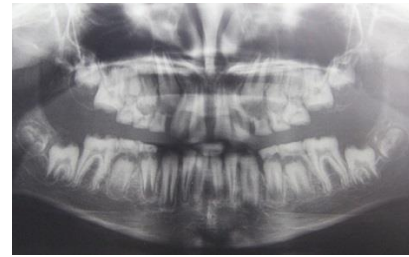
Orthopantomographic view
